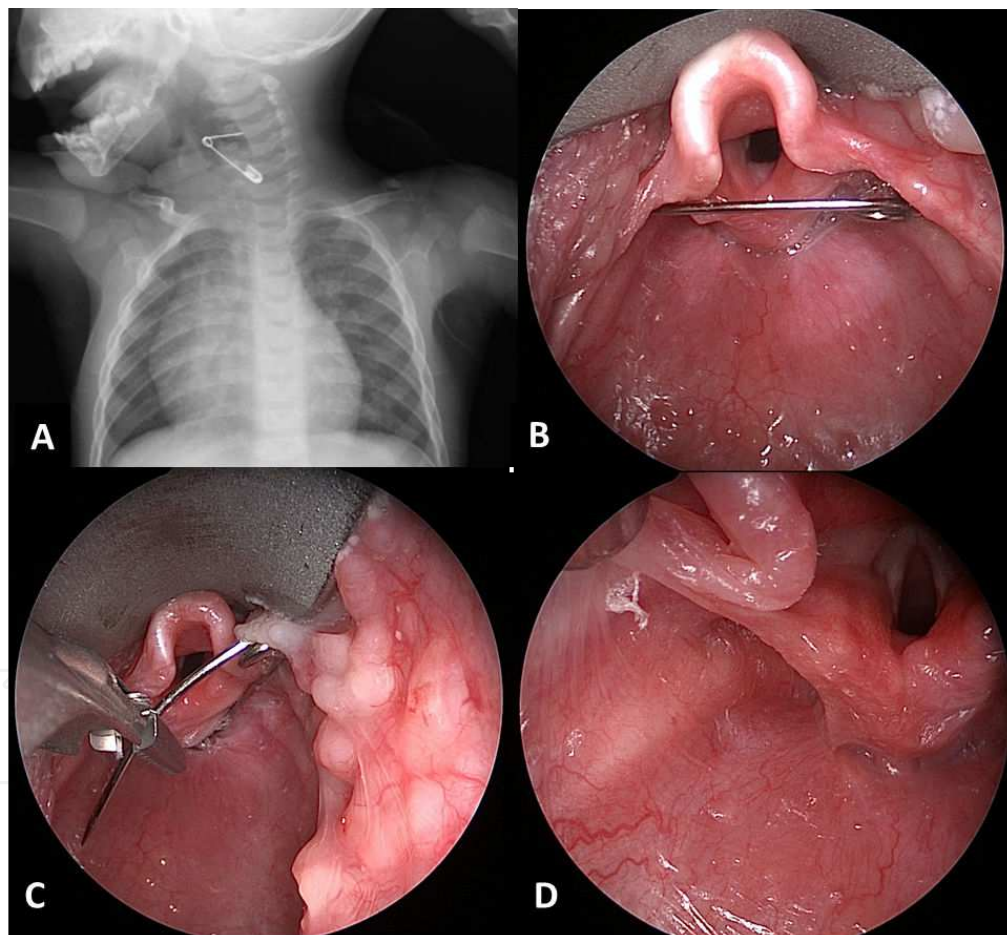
An 11-month old with an open safety pin in the upper airway. The patient presented with irritability and drooling of several hours duration, and the mother felt the child might have put something into its mouth. A-P and lateral plain films confirmed the diagnosis.
